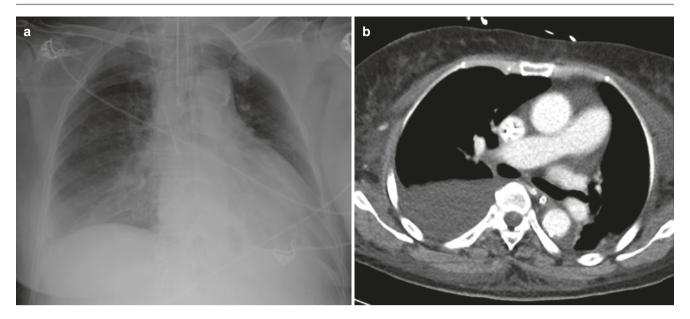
Pleural effusion. (a) Supine AP chest radiograph demonstrates diffuse hazy "veil-like" opacification of the right mid- and lower zones, often the only radiographic sign of pleural effusion in ICU patients. (b) Axial CT image shows moderate right pleural effusion
